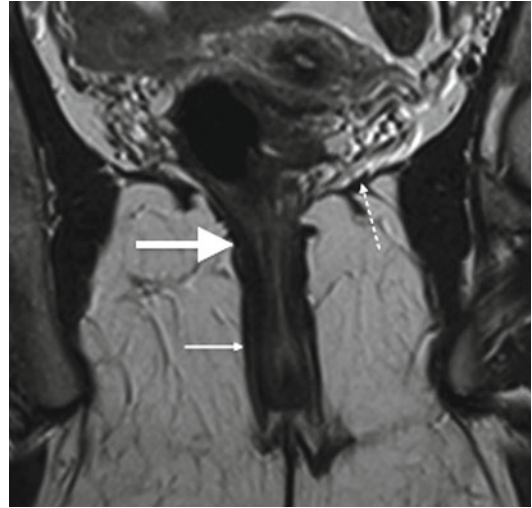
Coronal T2-weighted fast spin-echo MRI image of the anus: external anal sphincter (*thin arrow*), puborectalis (*thick arrow*) and levator ani (*dotted arrow*)
